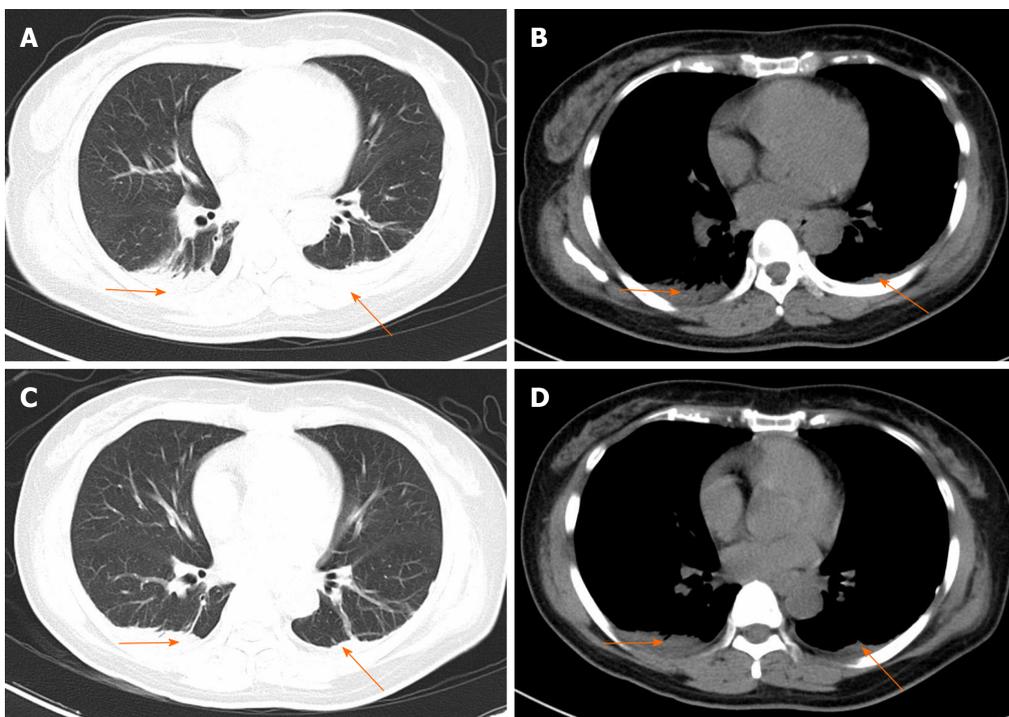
Chest computed tomography of postoperative day 10 and day 12. A and C: Pulmonary windows show bilateral small amount of effusion in 3 consecutive days (orange arrow); B and D: Mediastinal windows show bilateral small amount of effusion in 3 consecutive days (orange arrow).
